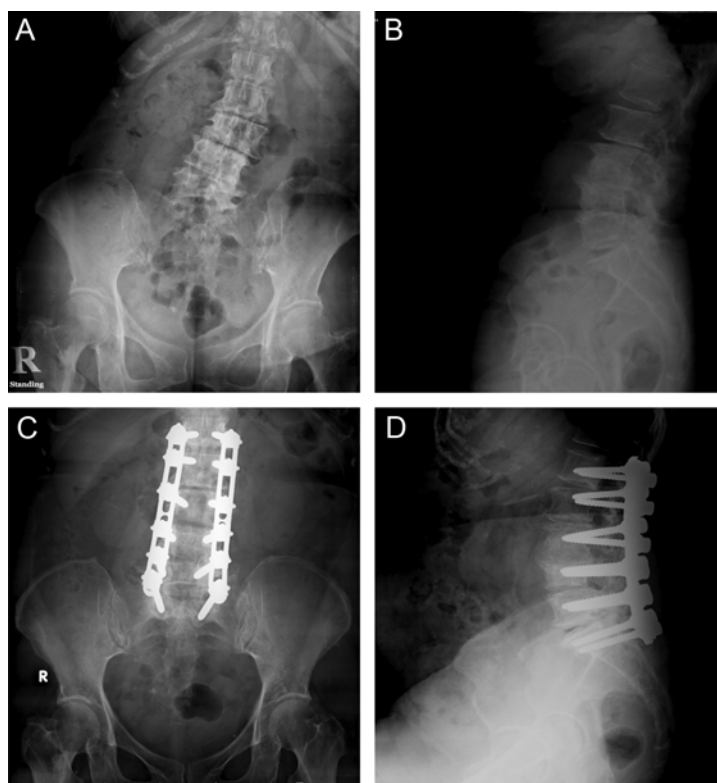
(A) and (B) Preoperative radiographs of degenerative scoliosis patient and (C) and (D) postoperative radiographs after decompression, reduction and correction using pedicular screw plate instrumentation
